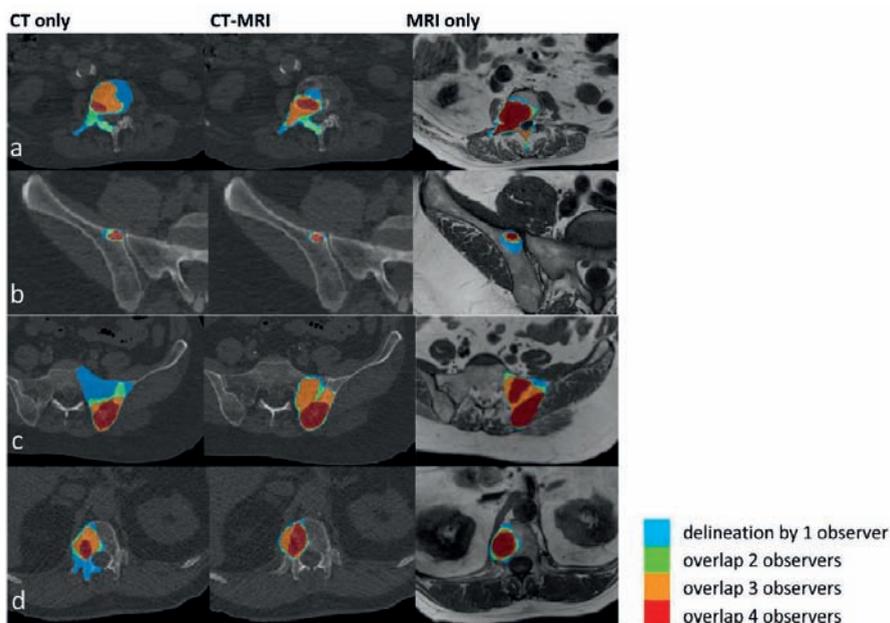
Delineations of 4 observers on transverse CT, CT with co-registered MRI sequences (visualized on CT) and T1-weighted MR images in 4 patients. a: case 6, b: case 11, c: case 18, d: case 20.
